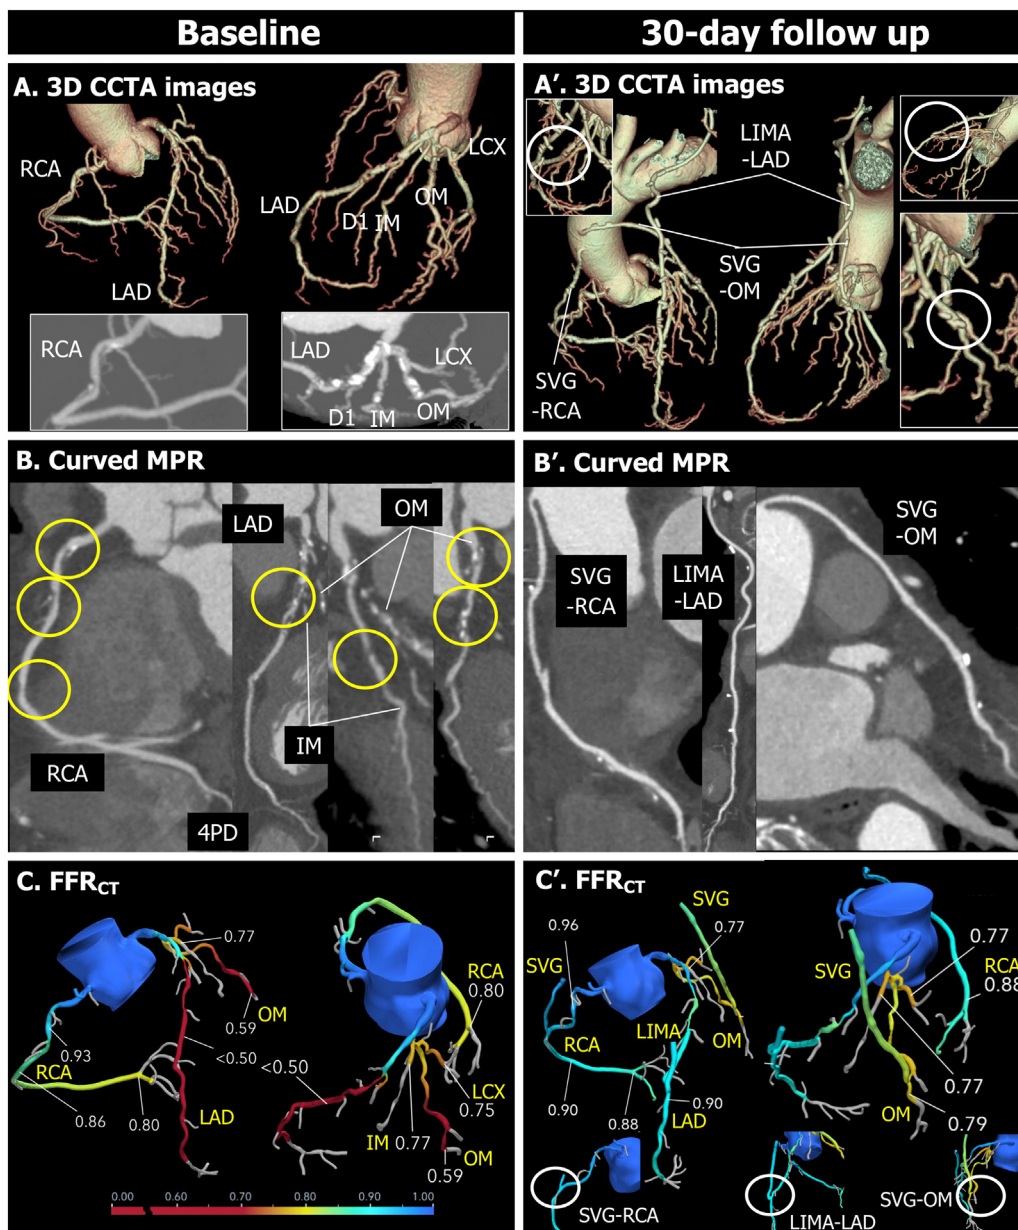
Panel A. 3D CCTA (VR and MIP) images at baseline. Panel A'. 3D CCTA images at 30-day follow-up post CABG. LIMA-LAD, SVG-RCA, and SVG-OM were grafted. White circles indicate the anastomoses. Panel B. Curved MPR images of CCTA of RCA, LAD, and LCX at baseline. Yellow circles indicate the significant stenoses based on the anatomical SYNTAX score calculation. Panel B'. Curved MPR images of CCTA of RCA, LAD, and LCX at 30-day follow-up post CABG. All the grafted vessels were patent. Panel C. FFR_{CT} findings at baseline. FFR_{CT} indicated flow-limiting lesions of the distal RCA, LAD, IM, OM, and LCX. Panel C'. FFR_{CT} findings at 30 days post CABG. The FFR_{CT} values of RCA, LAD, and OM were 0.88, 0.90, and 0.79, respectively. White circles indicate the anastomoses of LIMA-LAD, SVG-RCA, and SVG-OM.
